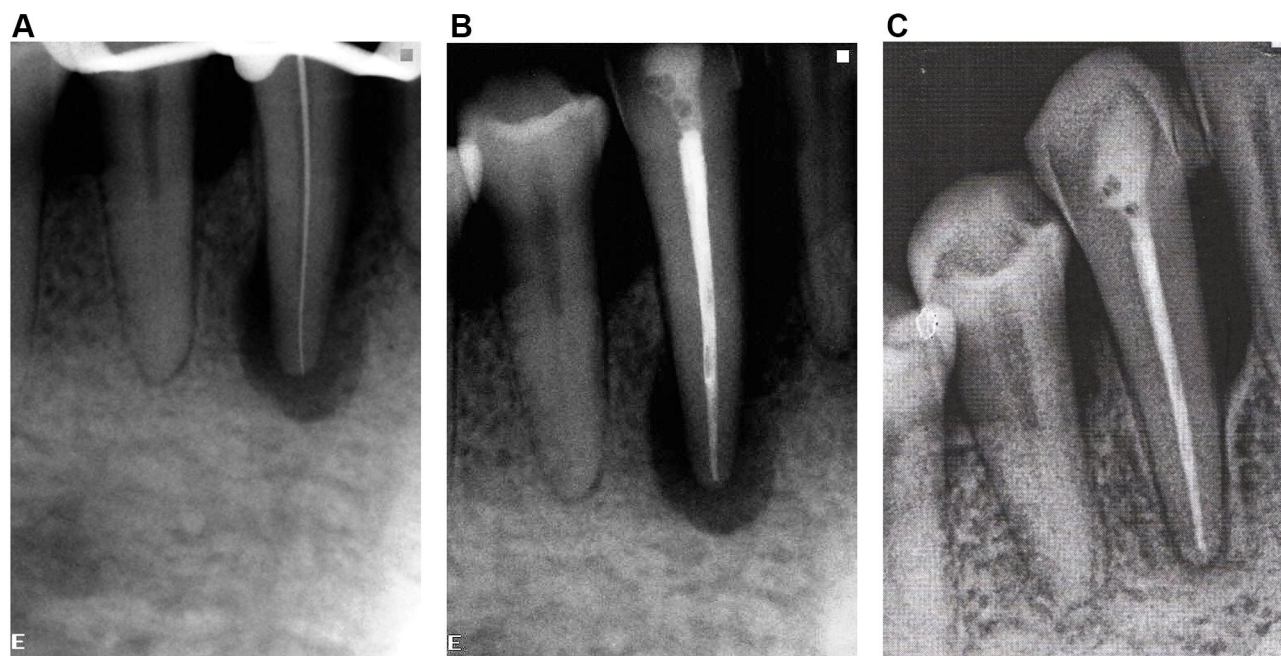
(A) Working length confirmation. (B) Immediately after obturation. (C) Six-month follow-up showing complete healing of the bone defect in the periapical area and interdental septum.
